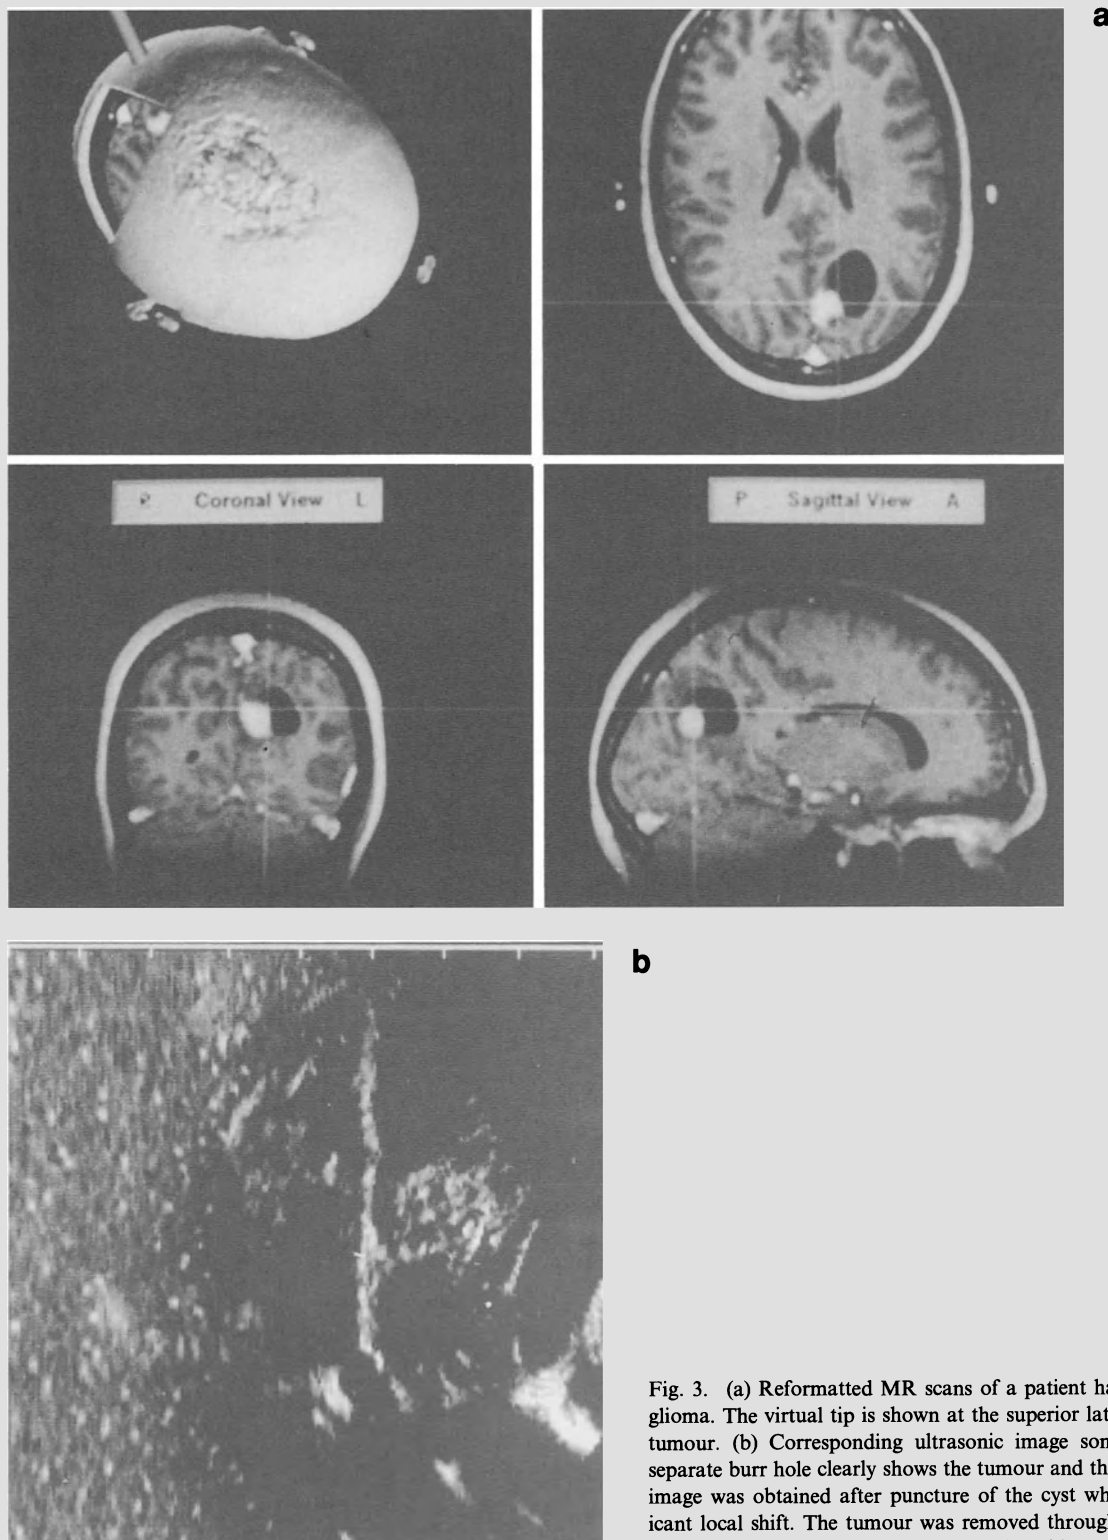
(a) Reformatted MR scans of a patient harbouring a cystic glioma. The virtual tip is shown at the superior lateral border of the tumour. (b) Corresponding ultrasonic image sonicated through a separate burr hole clearly shows the tumour and the falx cerebri. The image was obtained after puncture of the cyst which caused significant local shift. The tumour was removed through a small craniotomy and cortical opening with ultrasonic guidance
